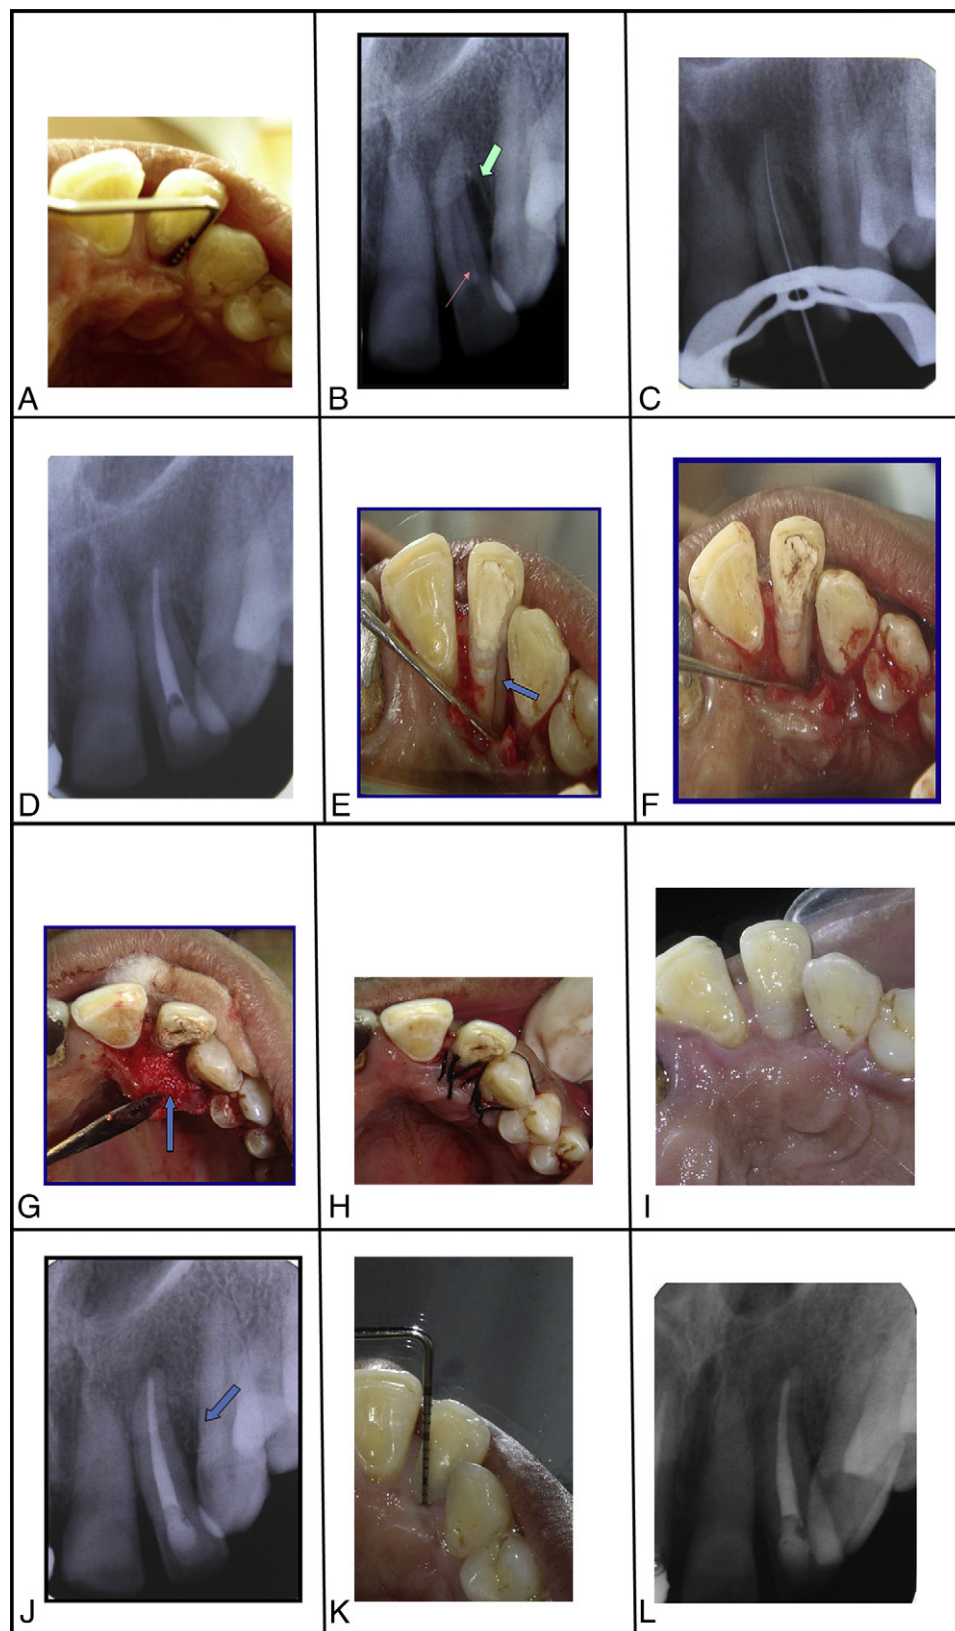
Lateral incisor showing palatogingival groove and its management. (A) Preoperative clinical; (B) preoperative radiograph, the pink arrow points to parapulpal radiolucent line and the green arrow points to a lateral periodontal defect; (C) working length radiograph; (D) postobturation radiograph; (E) surgical opening of palatogingival groove, as marked by the arrow; (F) sealing of palatogingival groove by using glass ionomer cement; (G) bone graft placement as marked by the arrow; (H) suturing; (I) postoperative 4 weeks; (J) postoperative radiograph at 4 weeks, the arrow points to filling in of the lateral defect; (K) postoperative 1 year; (L) postoperative 1-year radiograph. (This figure is available in color online at www.aae.org/joe/.)
